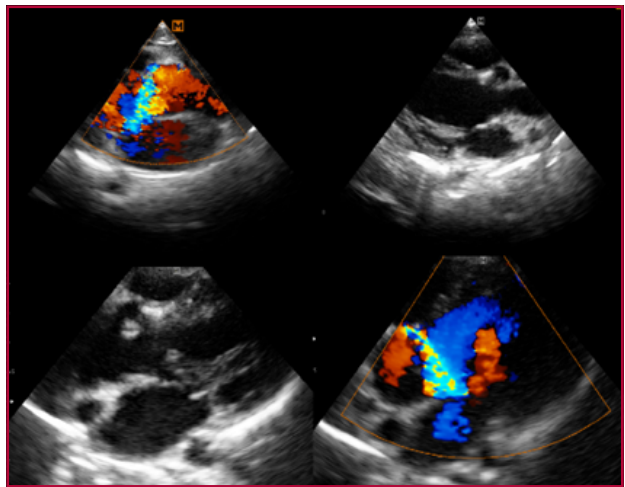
Transthoracic echocardiography: LV long axis and 5 chambers, showing regurgitant jet outside the aortic annulus.
